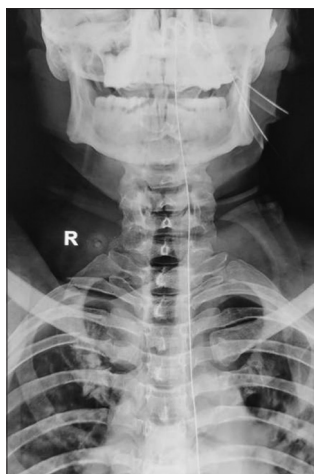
Plain radiograph anteroposterior view demonstrating C5 vertebral body fracture
